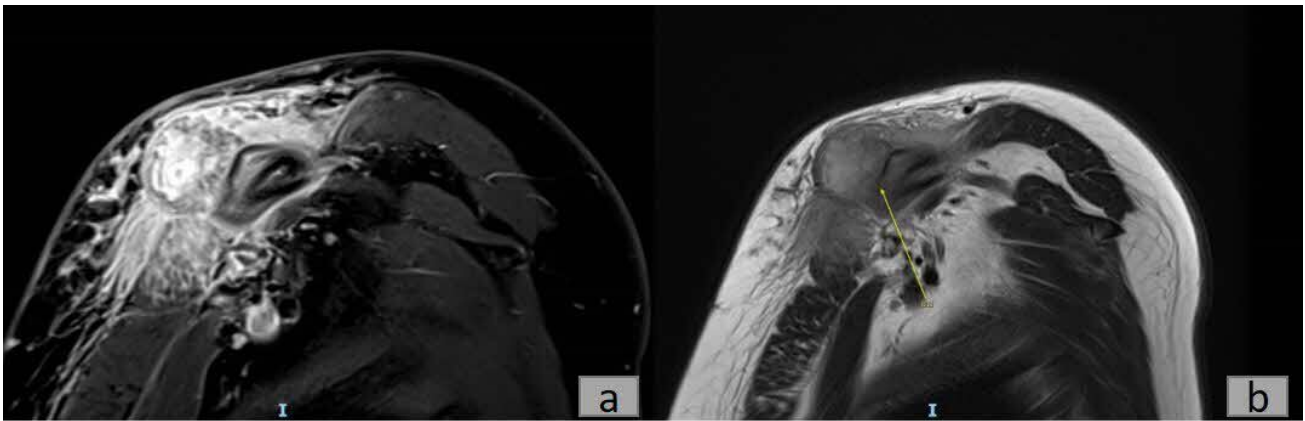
Sagittal T1 weighted MRI with contrast (a) and T2 fblade MRI (b) showing that the lesion is inseparable from the adjacent periosteum in some areas.
